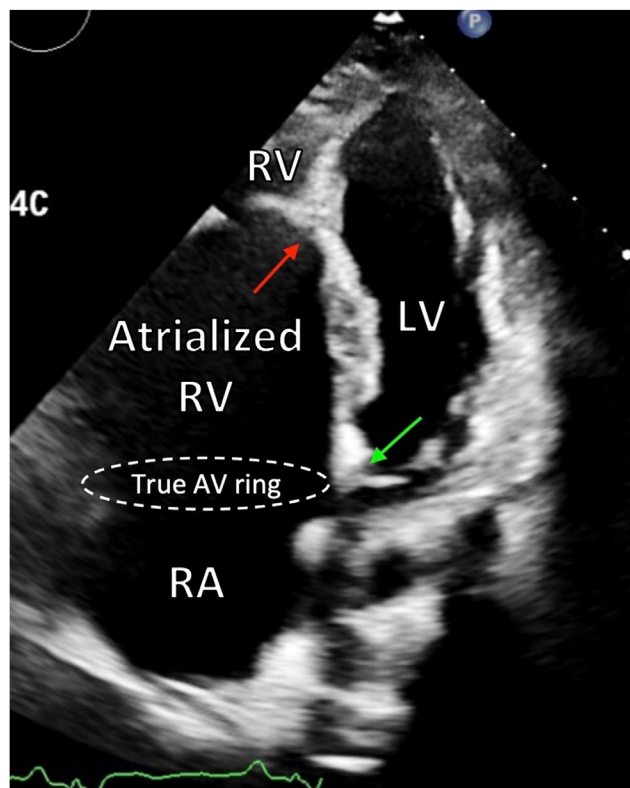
TTE, apical 4-chamber (4C) view at end systole with 50 mm (30 mm/m²) apical displacement of the septal leaflet hinge point (red arrow) in relation to the left AV valve (green arrow).
